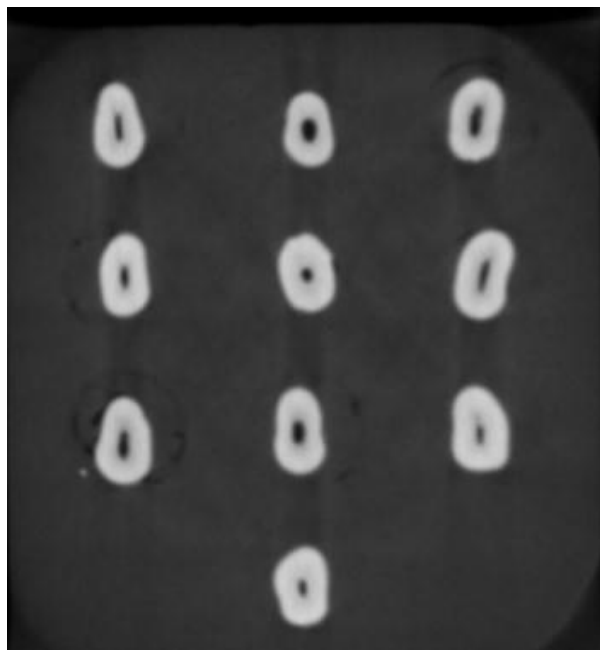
A photograph showing CBCT image of an axial view for the teeth.
